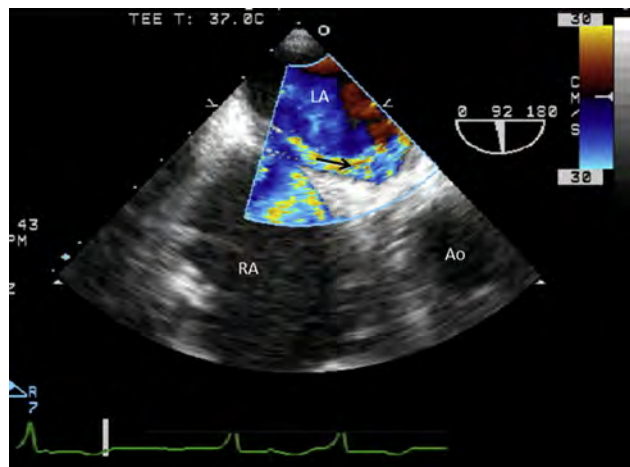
Perioperative TEE showing marked RA-to-LA shunting via an “unmasked” PFO, which became apparent immediately after LVAD activation. The PFO “tunnel”-defect shunt is readily apparent on color-flow Doppler (arrow) with a low Nyquist-limit setting of 30 cm/s. See also [Video 7](#).
